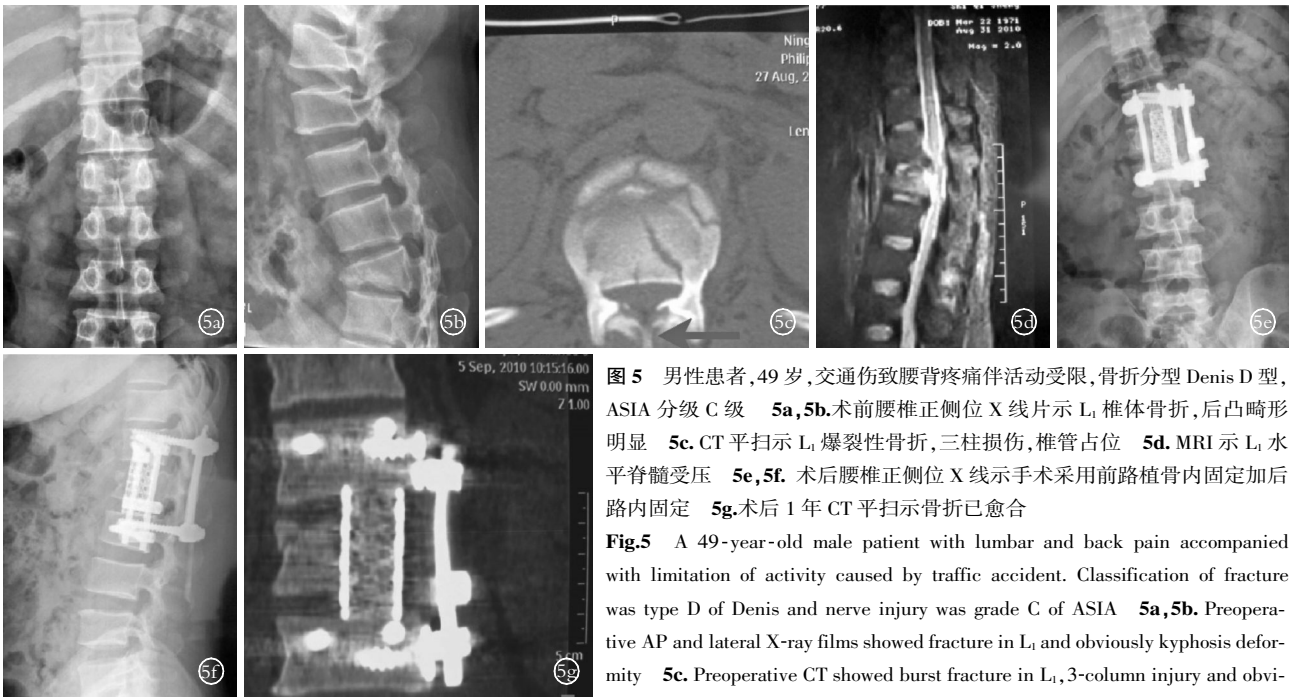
男性患者,49岁,交通伤致腰背疼痛伴活动受限,骨折分型 Denis D 型, ASIA 分级 C 级 5a,5b.术前腰椎正侧位 X 线片示 L₁ 椎体骨折,后凸畸形明显 5c. CT 平扫示 L₁ 爆裂性骨折,三柱损伤,椎管占位 5d. MRI 示 L₁ 水平脊髓受压 5e,5f.术后腰椎正侧位 X 线片示手术采用前路植骨内固定加后路内固定 5g.术后 1 年 CT 平扫示骨折已愈合
